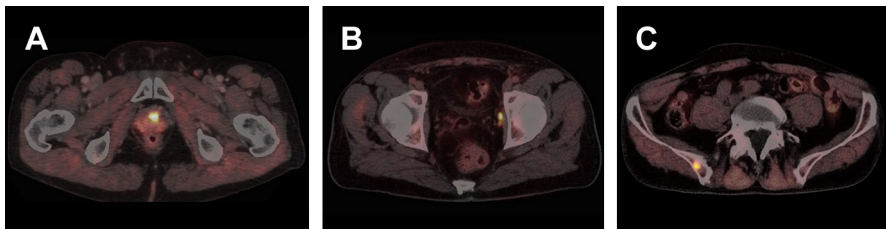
^{18}F -fluciclovine PET/CT images showing local recurrence (A), a lymph node metastasis (B), and a sclerotic bone metastasis (C).
